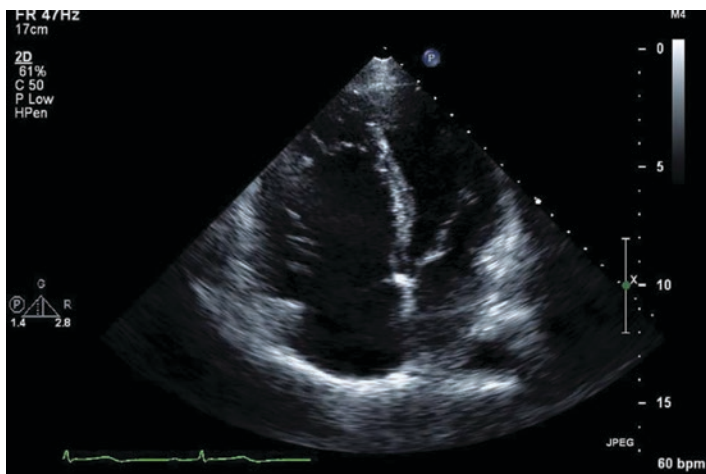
Transthoracic apical four-chamber view of a patient with Ebstein's anomaly showing apical displacement of the septal leaflet of the tricuspid valve and a small-sized functional right ventricle
